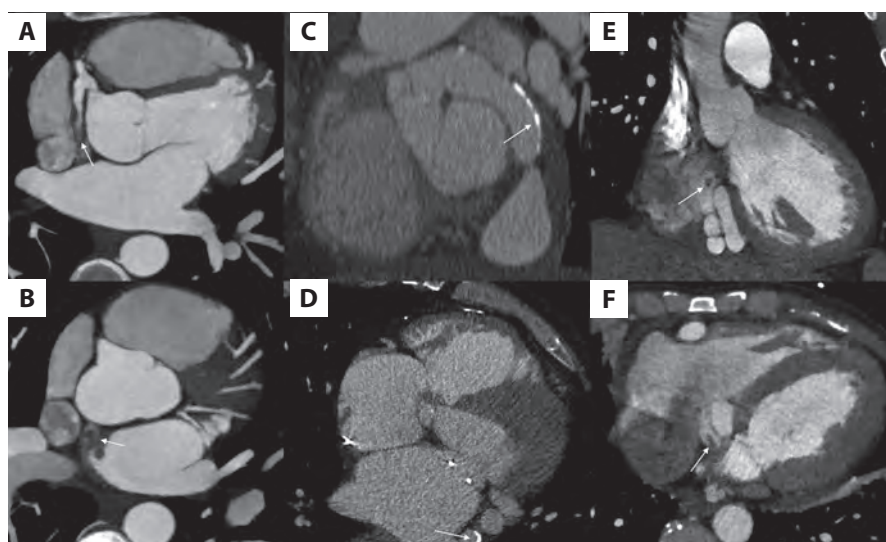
Coronary CT, MPR. A. Cross-sectional view, CAF between the RCA and the LA (arrow). B. Distal segment of CAF with thrombus (arrow). C. Oblique cross-section, calcification within CAF (arrow). D. Cross-sectional view, calcification within CAF (arrow). E-F. Vegetation at the site of termination of CAF draining into the right atrium (arrow), frontal view (E), cross-sectional view (F)
